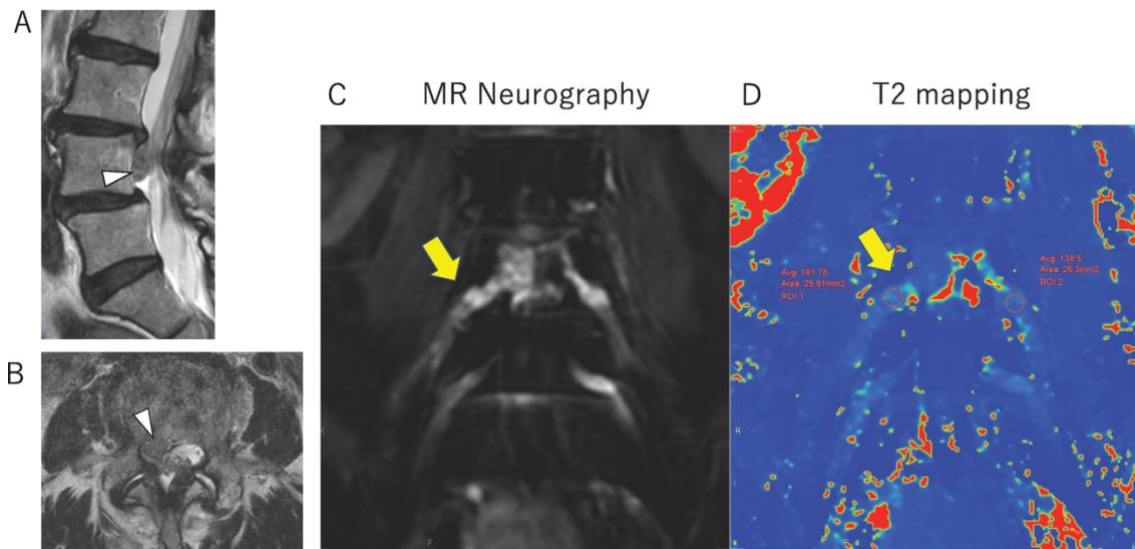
A 72-year-old woman with lumbar intervertebral disc herniation. A, B) MRI (T2-weighted image) of the lumbar spine. A) Sagittal image. Herniation of the L3/4 intervertebral disc was observed (arrowhead). B) Axial image of L3/4. Right- side intervertebral disc herniation was observed (arrowhead). C) Lumbar MR neurography (coronal image) indicated swelling of the right L4 nerve (arrow), and D) Lumbar T2 mapping (coronal image) indicated that the DRG T2 relaxation time was 181 ms on the involved side and 97 ms on the intact side (increased on the involved side).
